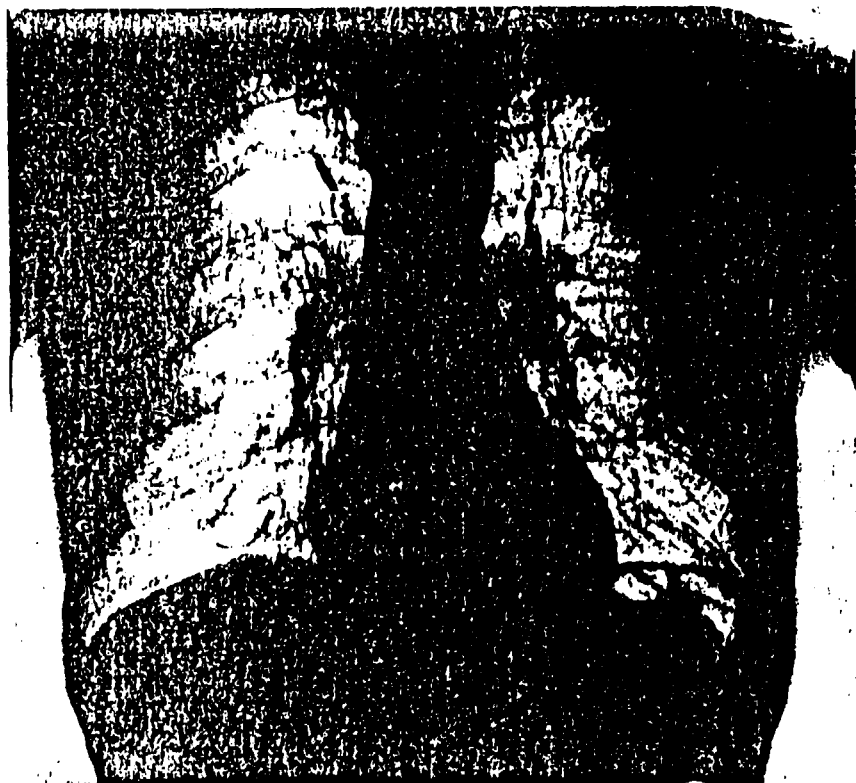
Rectitude of diaphragm (posteroanterior x-ray) in an asbestos-exposed worker.
